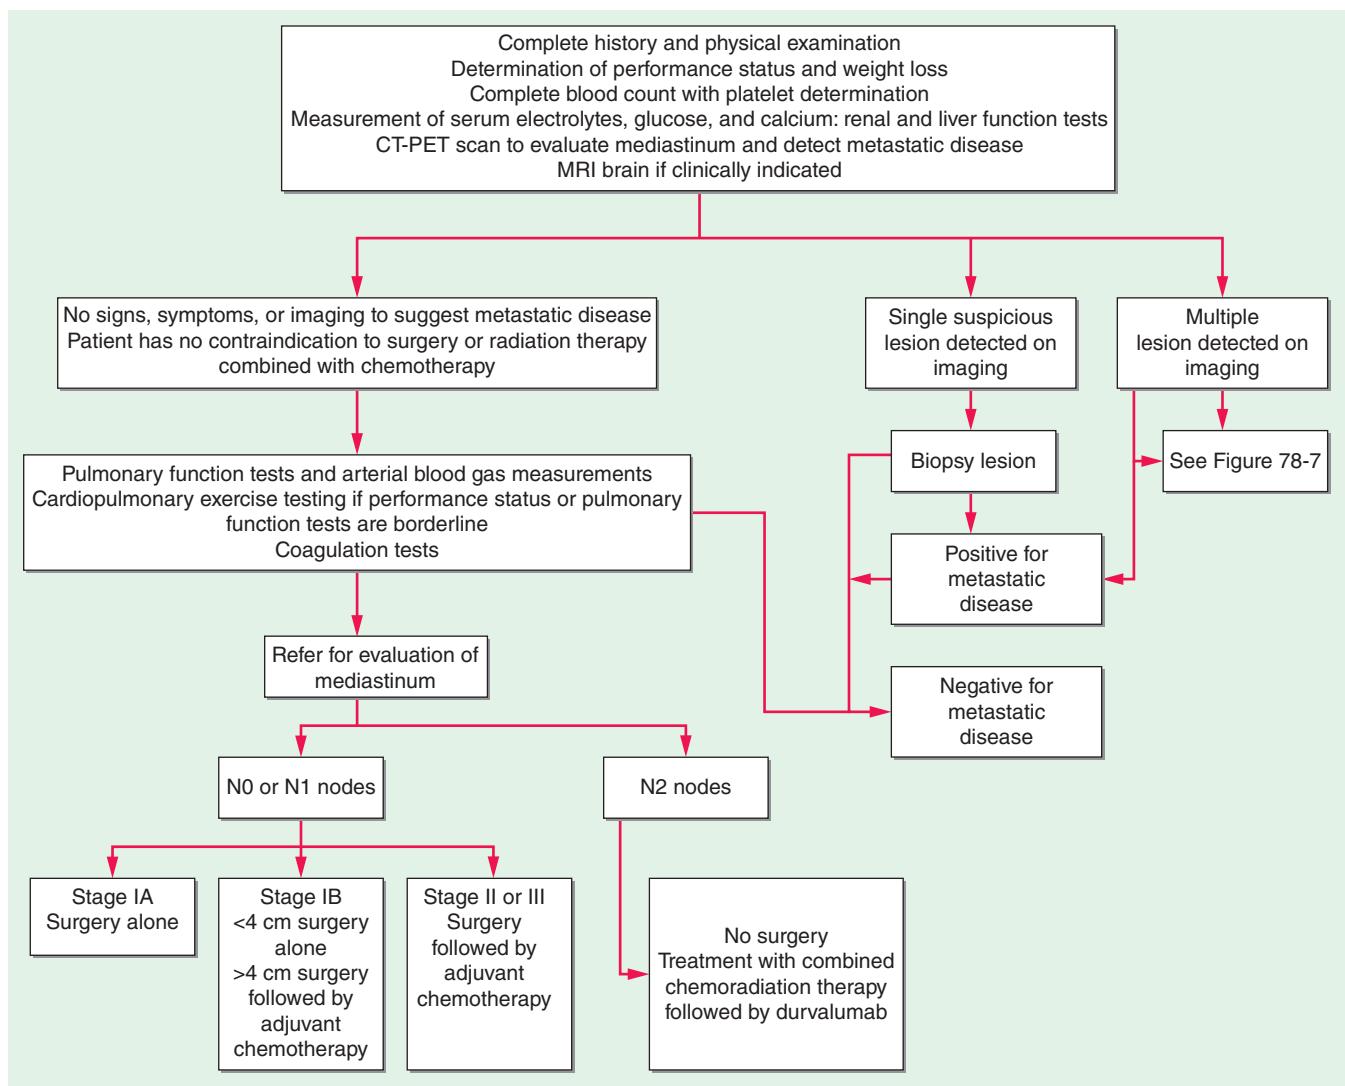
Algorithm for management of non-small-cell lung cancer. MRI, magnetic resonance imaging; PET, positron emission tomography.
